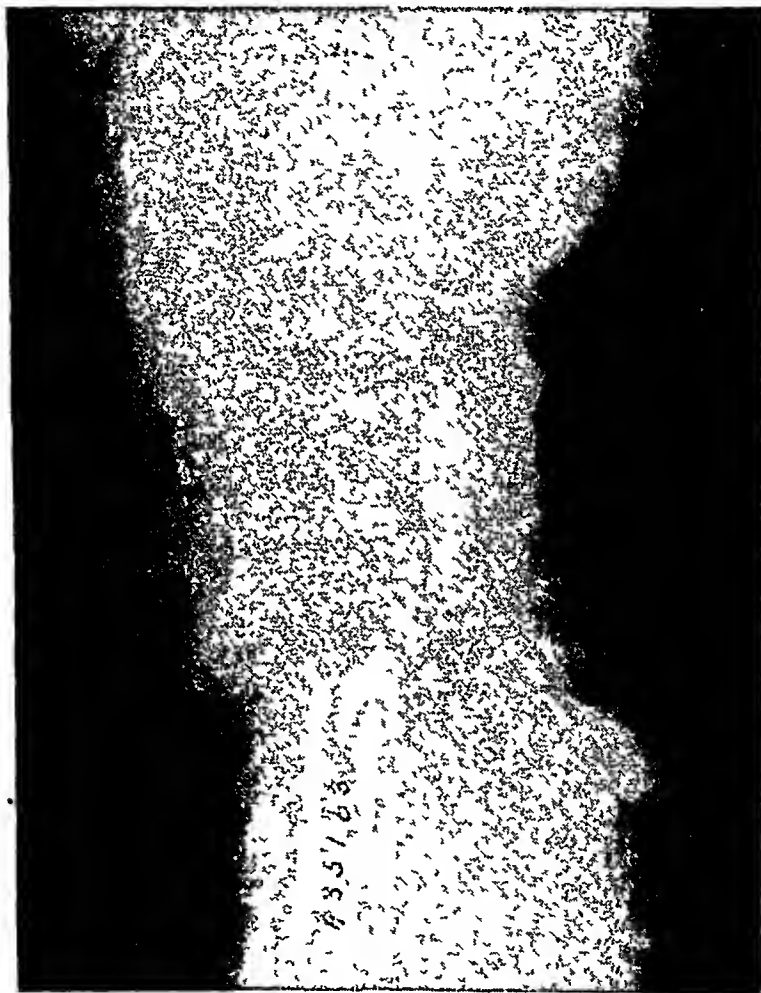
Roentgen-ray showing the complete block of the Lipiodol between the second and third lumbar vertebrae. The irregular conical shape is very suggestive of adhesions.
